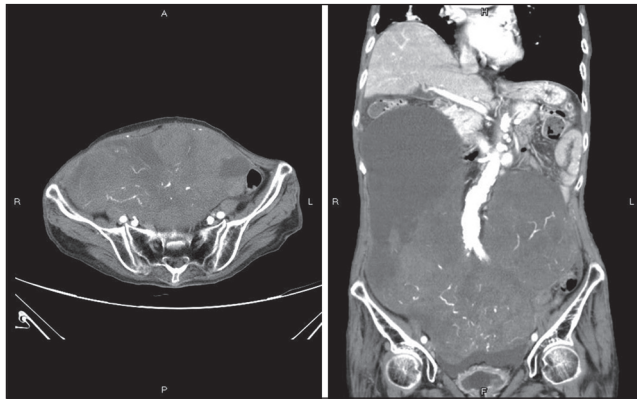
Computed tomography shows a well-defined giant mass occupies the abdominopelvic region with heterogeneous density and cystic changed
